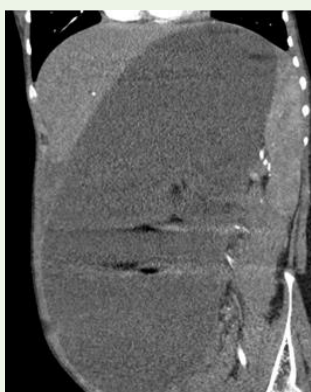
Contrast enhanced CT showing gross dilatation of stomach.
